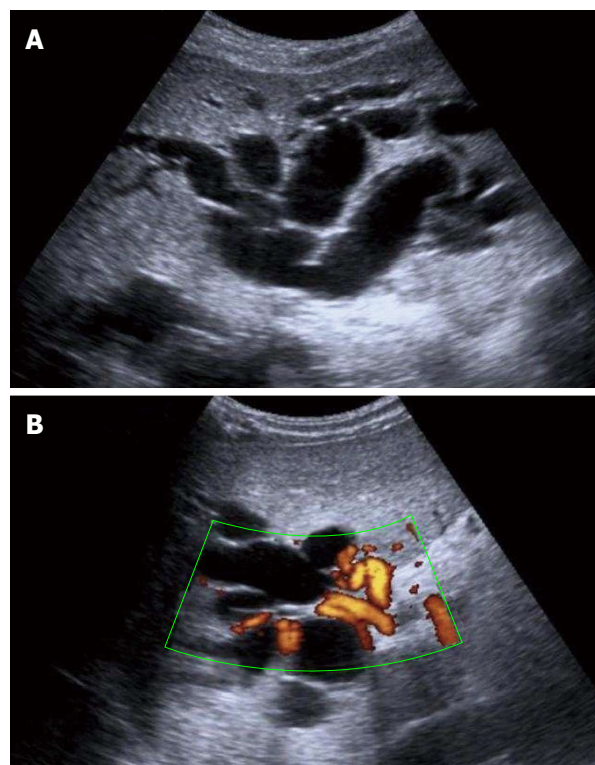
Ultrasound examination. A: Ultrasound examination showing dilatation of the intrahepatic bile ducts; B: Doppler ultrasound examination demonstrating cavernomatous degeneration of the portal vein with hilar collateral circulation.
